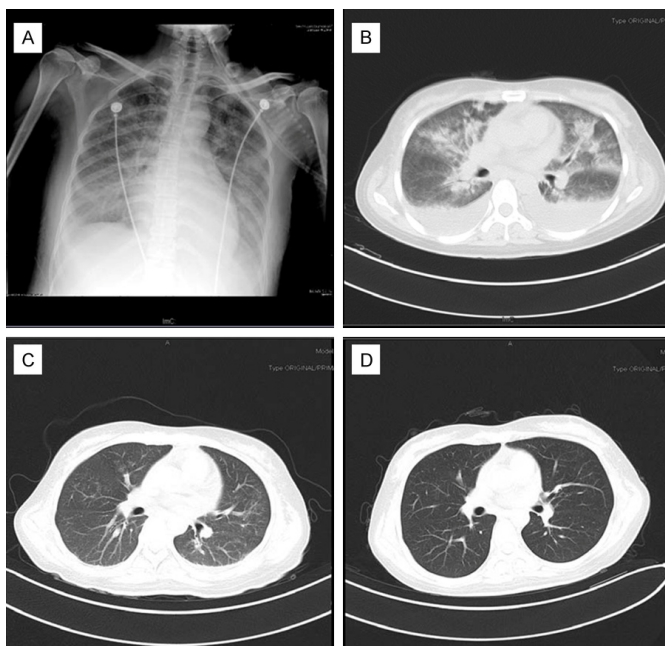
A. Chest X-ray son admission showed diffuse alveolitis and infiltrates in both lungs. B. Chest CT scan on admission showed bilateral pulmonary patchy opacities, pulmonary edema, a ground glass pattern and pleural effusion. C. Chest CT scan on the 12th hospital day showed significant resolution of pulmonary infiltrates, pulmonary edema and pleural effusion. D. Chest CT scan on discharge showed bilateral pulmonary opacities and pleural effusion disappeared.
